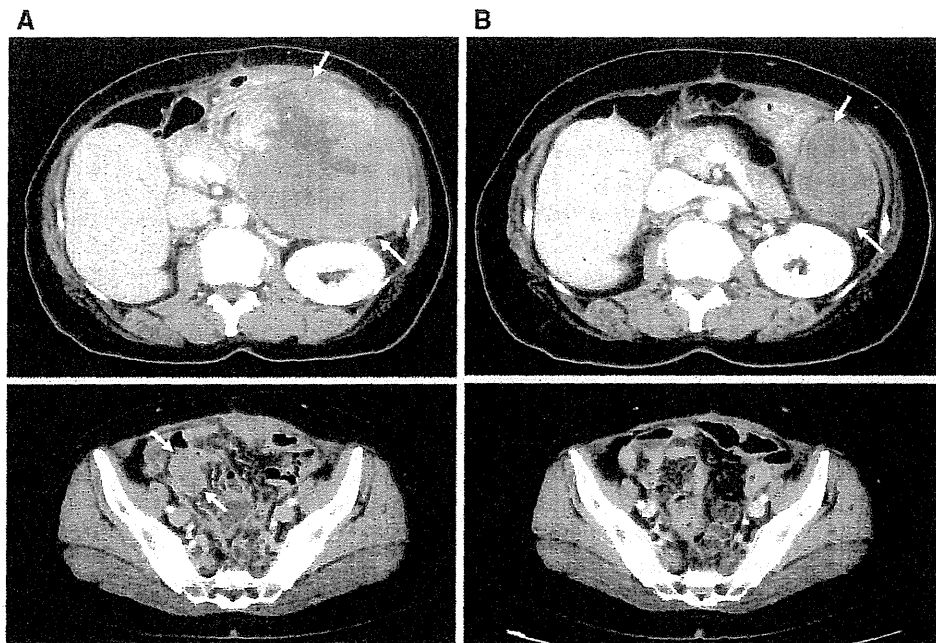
Images of CT scan before and after anastrozole treatment. a Recurrent tumors with 13 cm in diameter in the left upper quadrant (*Upper*) and 4 cm in diameter in the pelvis (*Lower*). b The recurrent
